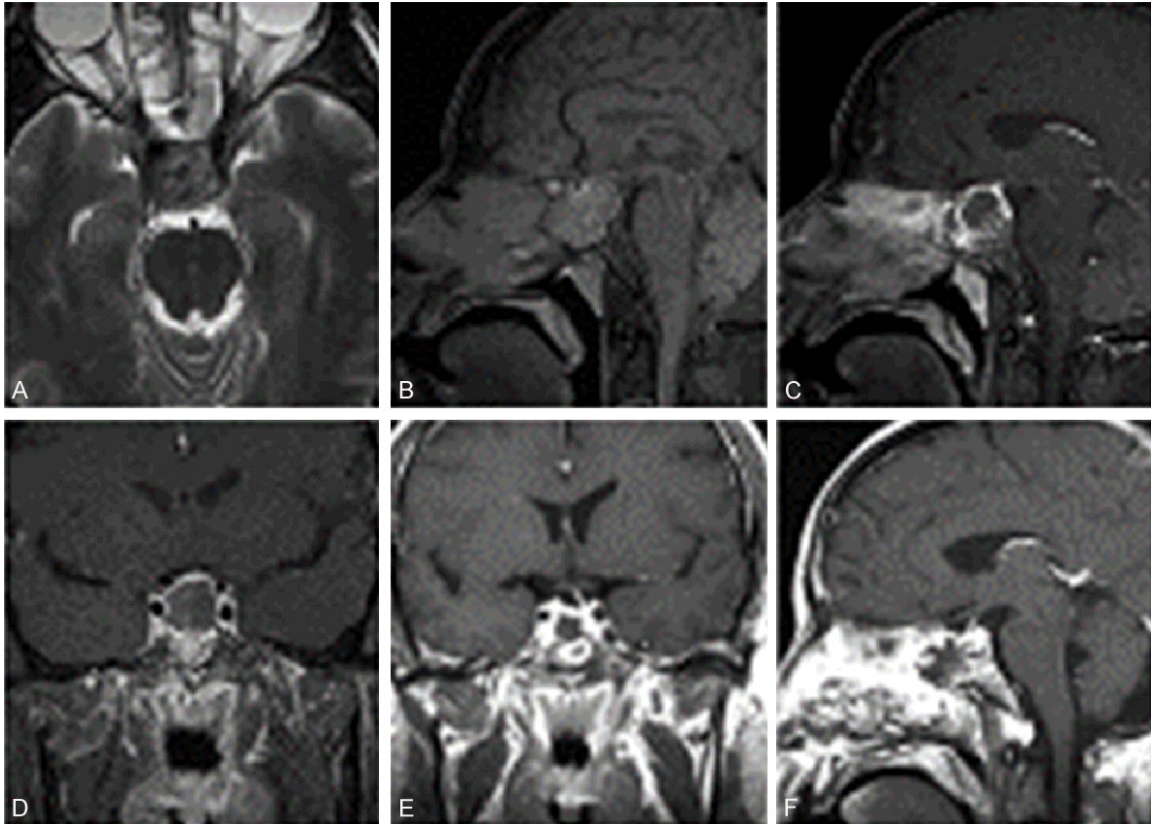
Imaging manifestations of case No. 8. (A) Axial T2WI, (B) sagittal T1WI, (C) sagittal T1+, and (D) coronal T1+ MRI before surgery. T1WI mainly shows high signals; T2WI mainly shows low signals. (E) Coronal T1+ and (F) sagittal T1+ MRI four months after surgery. MRI, magnetic resonance imaging.
